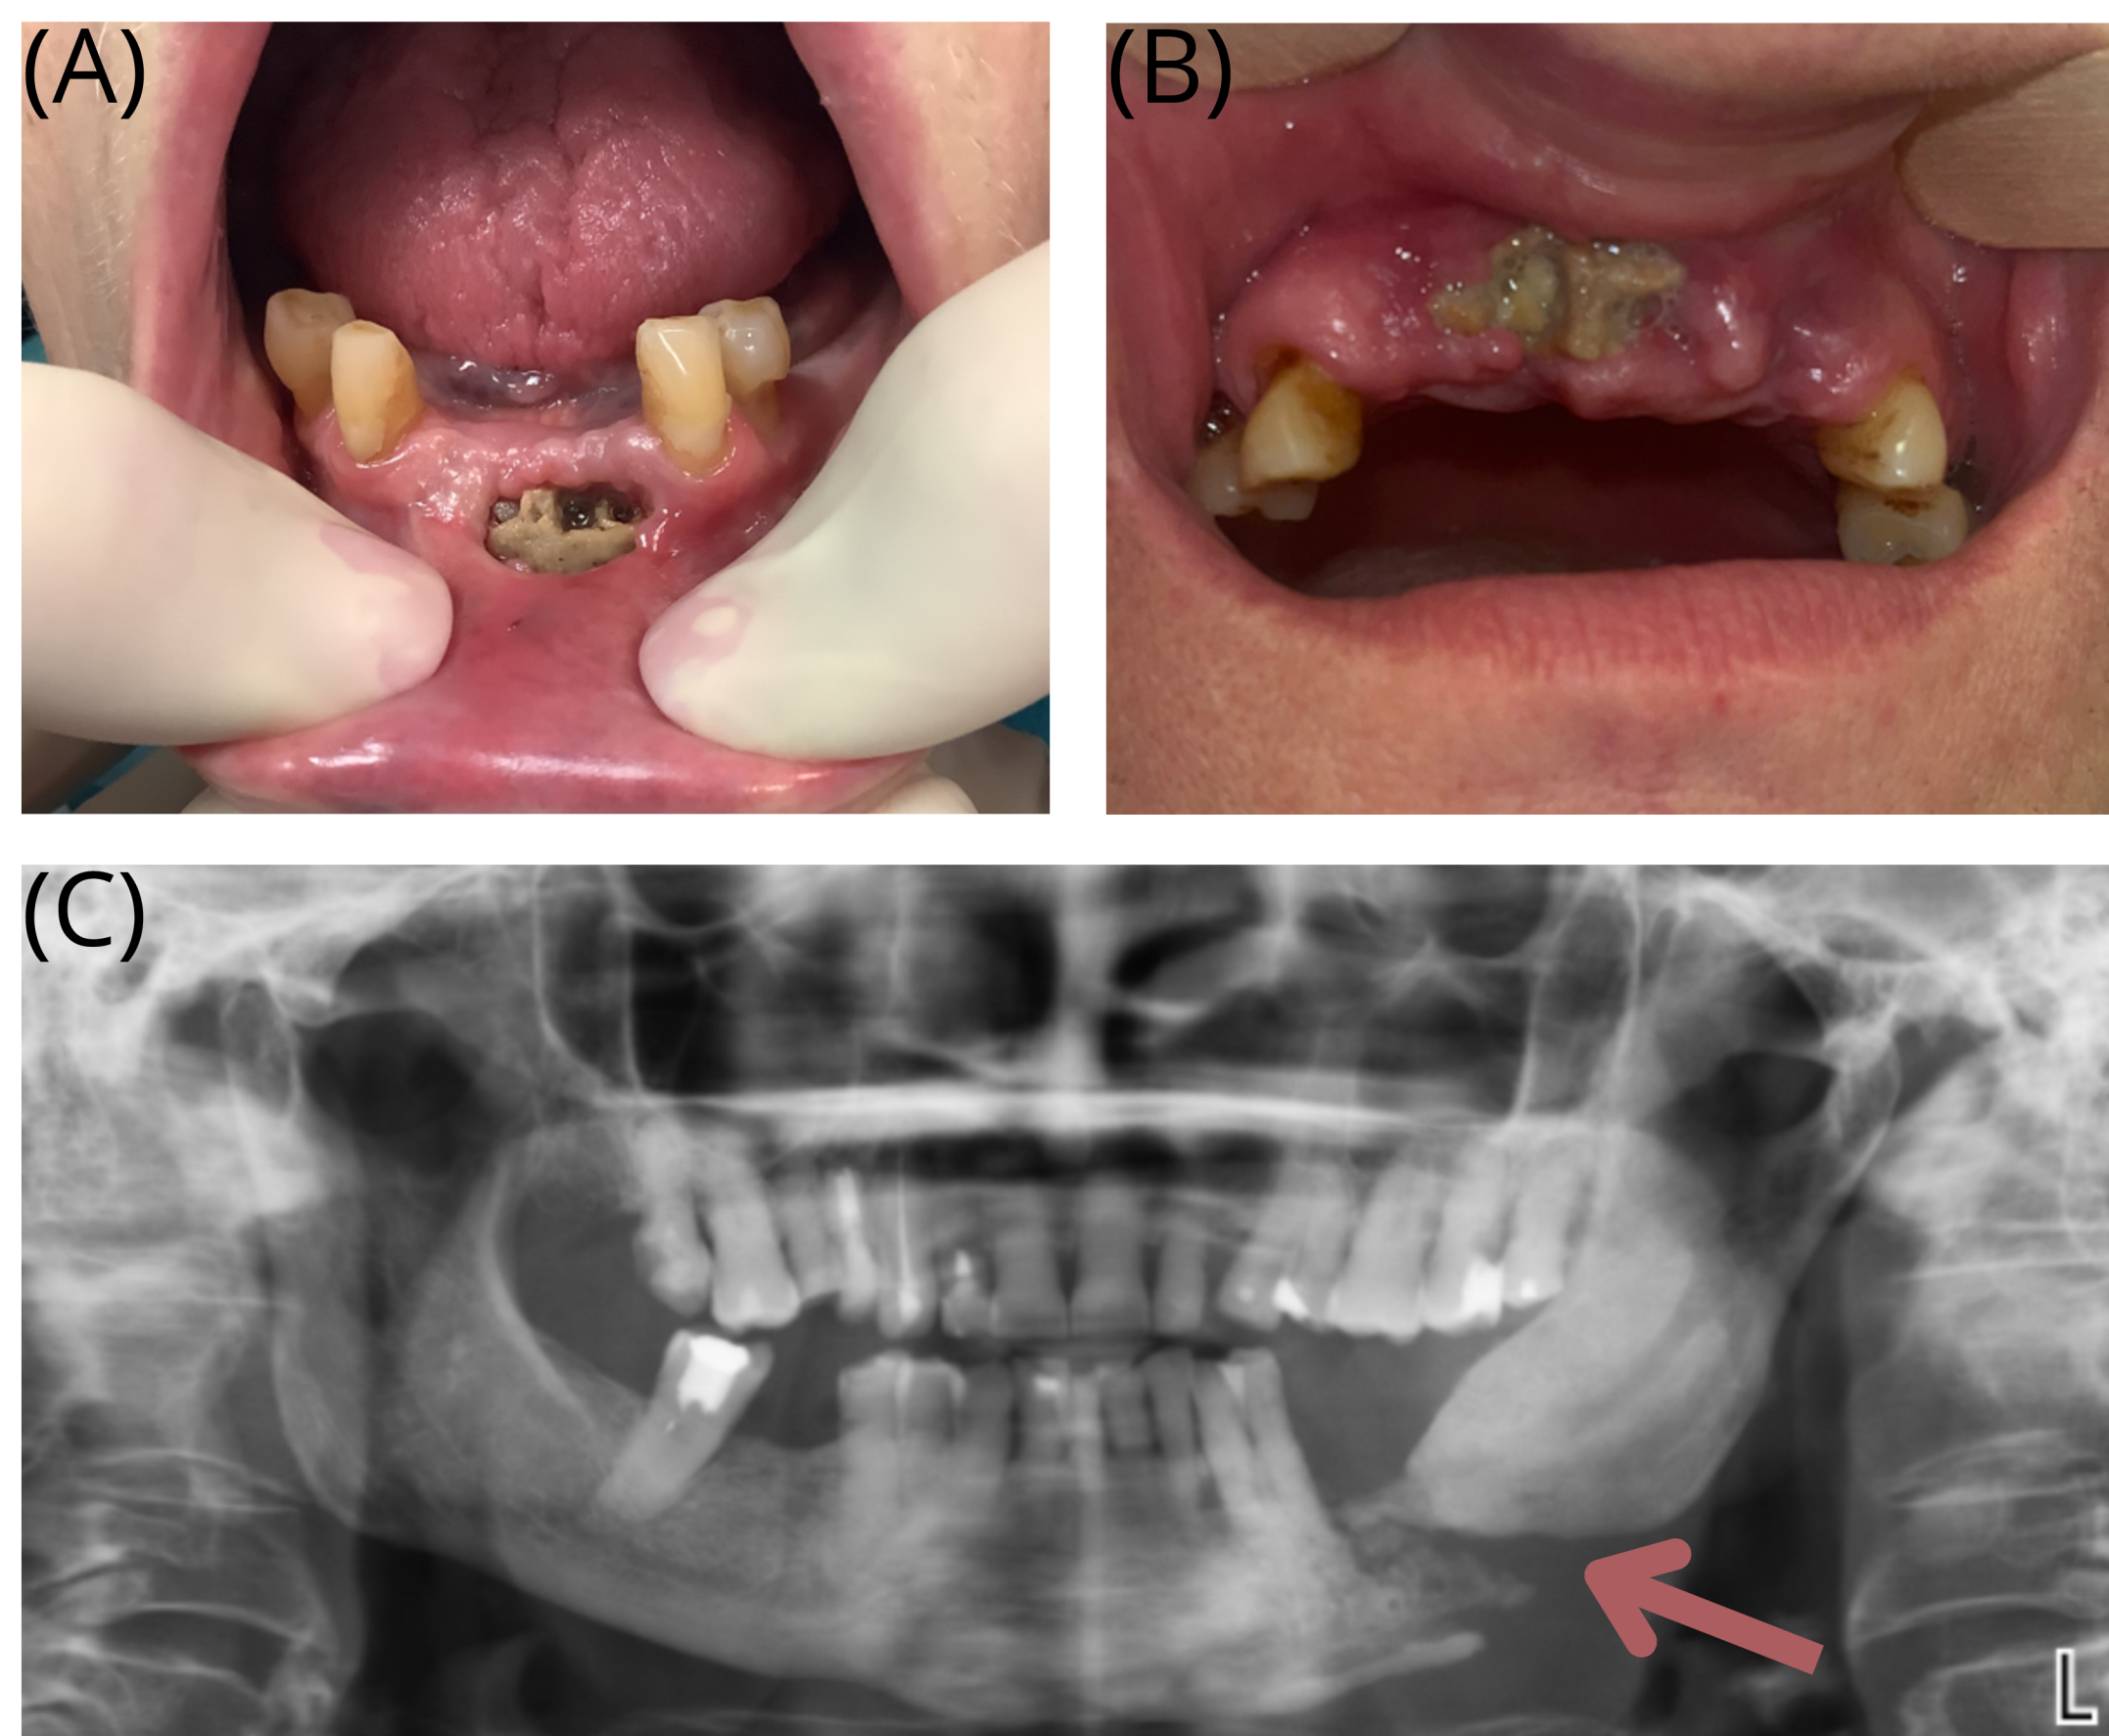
Clinical and radiographic manifestations related to MRONJ.
